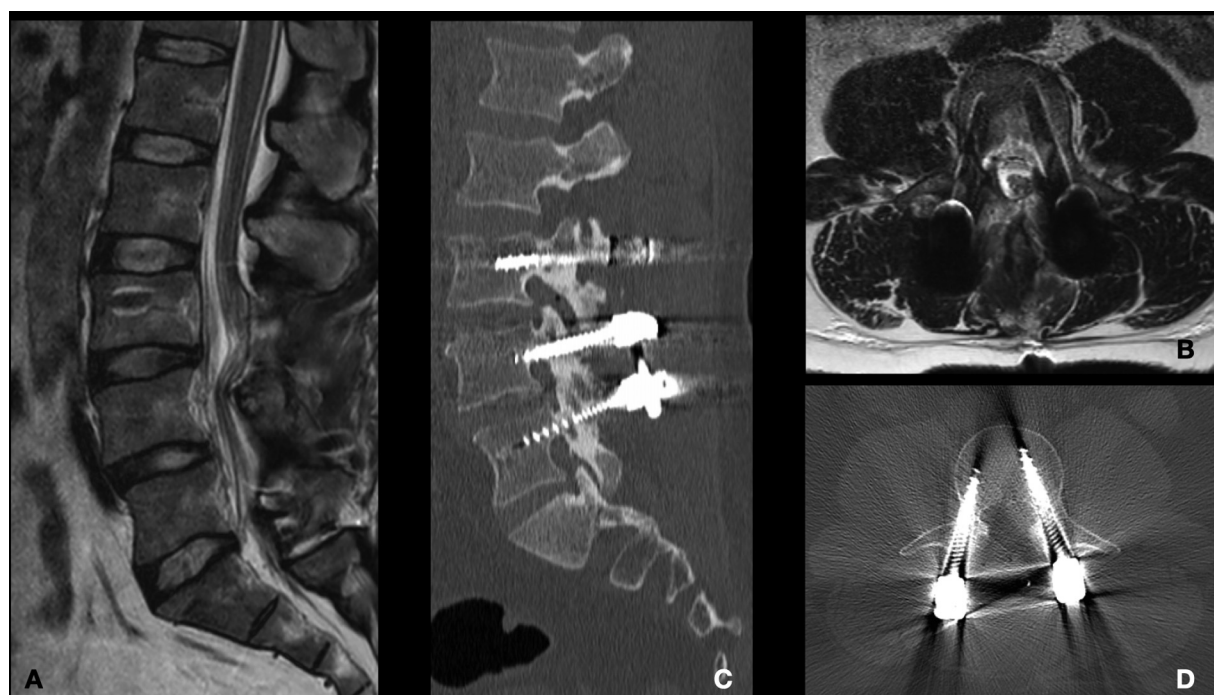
(A) Sagittal and (B) axial views of the postoperative T2-weighted magnetic resonance imaging showing decompression of L3-L4. (C) Sagittal and (D) axial postoperative computed tomography showing correct screw placement.
